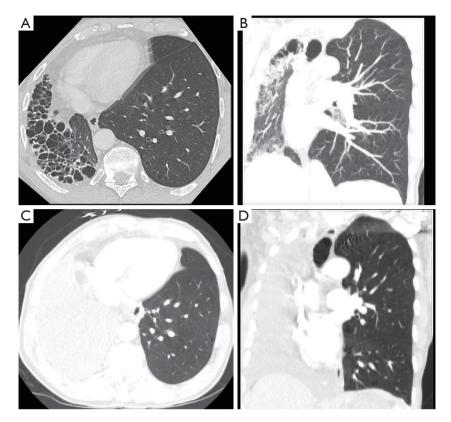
Patient's CT scans pre- and post-operatively. (A,B) Axial and coronal pre-operative CT images, respectively, showing hypoplasia and diffuse cystic changes in the right lung. (C,D) Post-operative CT images showing successful right sided pneumonectomy. CT, computed tomography.
